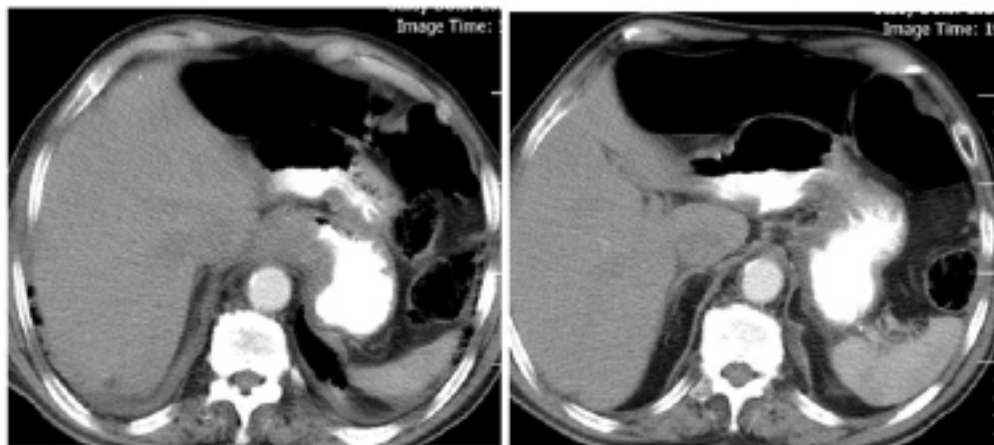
CT-scan of the chest show (IHE) lower portion of esophageal and EGJ with hematoma.
